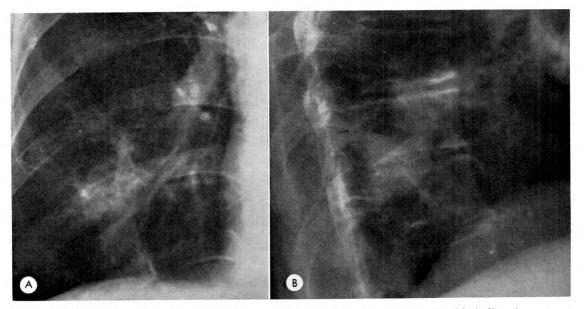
(A) Posteroanterior roentgenogram of the right upper lobe showing a nonspecific infiltrative process without clear definition. (B) Lateral roentgenogram of the same lesion demonstrating the characteristic rounded and oval configuration of the mucoid impaction.
